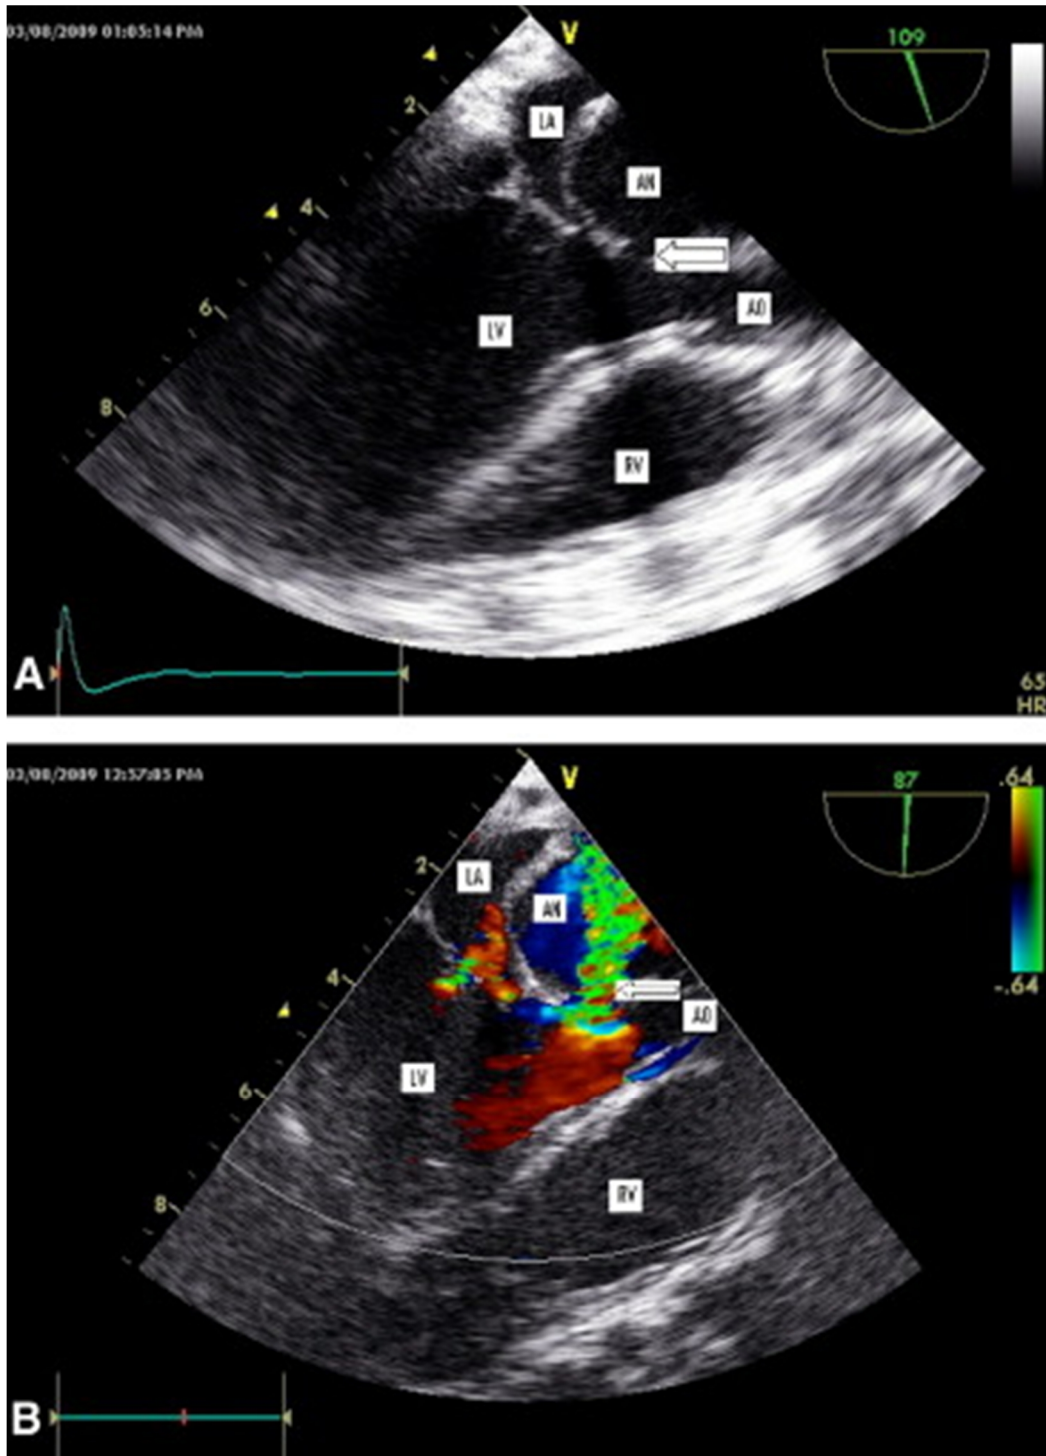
Transesophageal echocardiogram: (A) demonstrating the large subaortic aneurysm compressing the left atrium and narrow neck (arrow). (B) With color Doppler showing the restrictive flow through the neck of the aneurysm (arrow). (AN = aneurysm; AO = aorta; LA = left atrium; LV = left ventricle; RV = right ventricle.)
